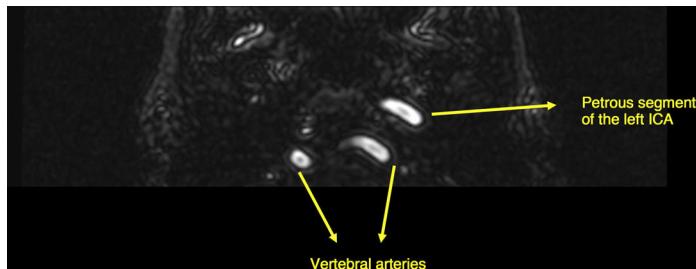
Intracranial MRI angiography.
